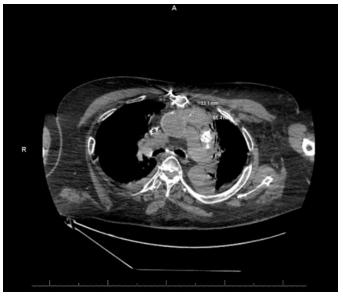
CT chest, 2021—showing reduction in anterior mediastinal mass size compared to prior (Figure 2).
